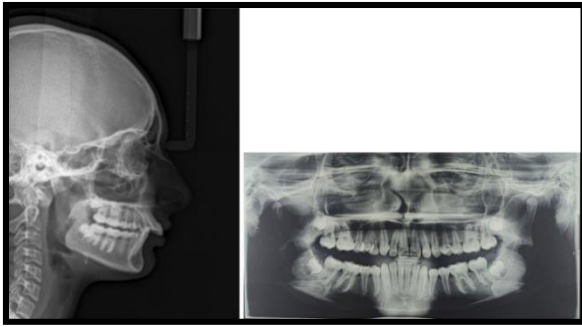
Pre-treatment x-rays (a) Lateral cephalogram
